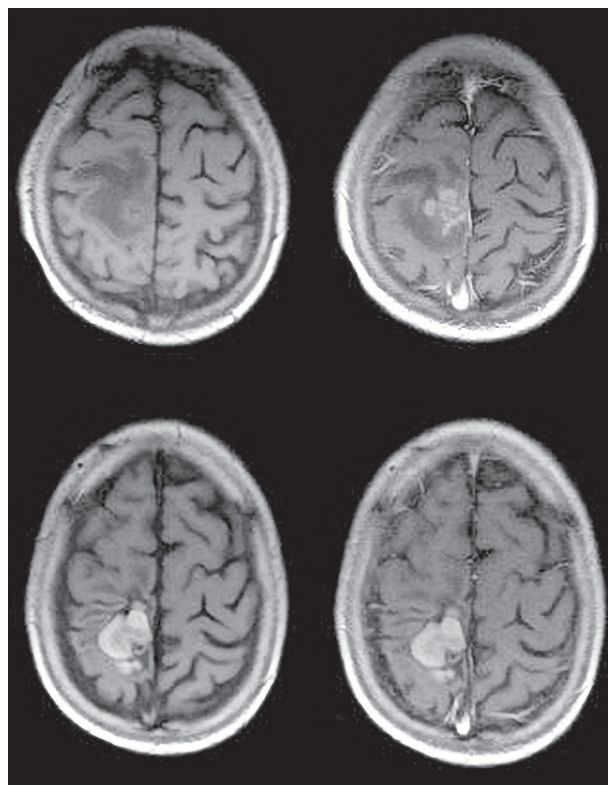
MRI examination from day +50 (top) after transplantation and 18 months after transplantation (bottom). Left: Axial T1-weighted sequence. Right: Postgadolinium sequence.
